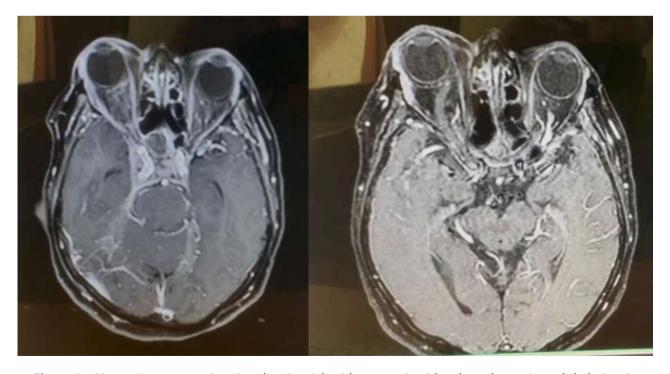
Magnetic resonance imaging showing right side proptosis with enlarged superior ophthalmic vein
